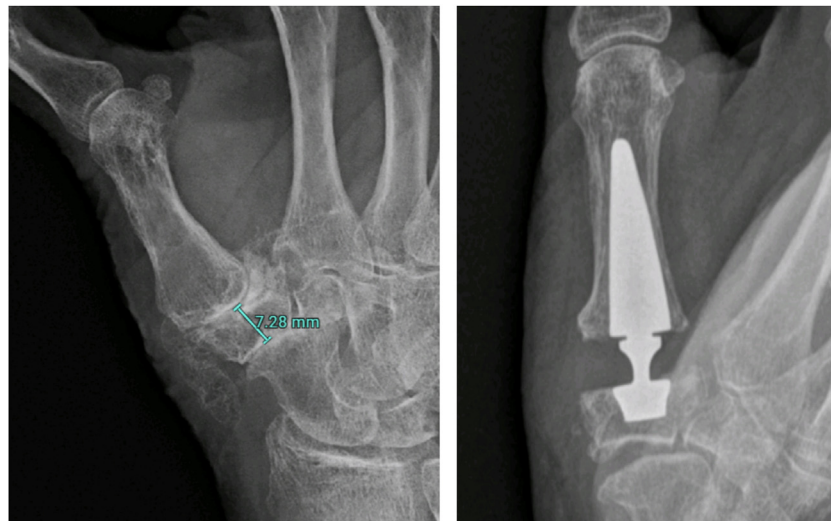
Radiographic measurement of trapezium height and postoperative radiograph after insertion of conical cup with depth of 4.3 mm.
